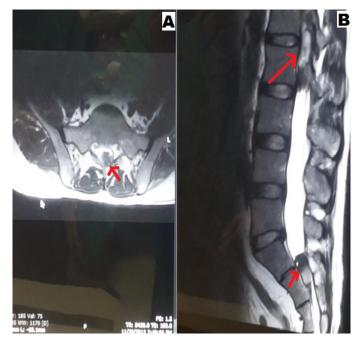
A 31-year-old male was referred to our emergency department with an unsteady gait, left leg numbness and weakness of seven weeks' duration. Retention of urine was developed over the past three days. Preoperative MRI demonstrated the presence of two well-circumscribed intradural extramedullary lumbar lesions at L1-2 and S2 levels. The lesions were hyperintense on T1WI and iso-hyperintense on T2WI. A) Axial T2WI at S1 level. B) Sagittal T2WI. GTR was performed for both lesions with two laminectomies. The lesions were confirmed to be WHO grade II classic ependymoma. The neurological examination did not change even after the patient underwent 30 sessions of physical therapy and rehabilitation. No recurrence or seeding was detected on his 272th control visit. Red arrows indicate the lesions
